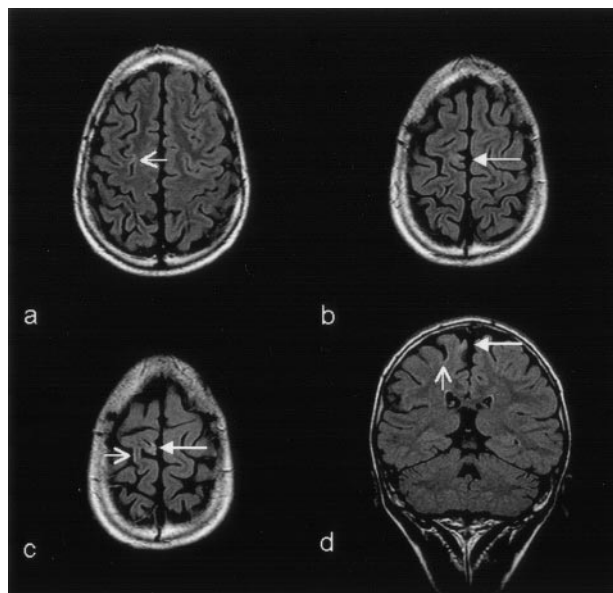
Scarring of the left superior frontal gyrus. Axial 5-mm-thick (a–c) and coronal 3-mm-thick (d) FLAIR fast spin-echo images show an atrophic and hyperintense lesion in the right superior frontal gyrus (solid-head arrows in a–d). Note also a tiny increase in signal intensity and the atrophy in the depth of the right frontal superior sulcus (open-head arrows in a, c, and d).
